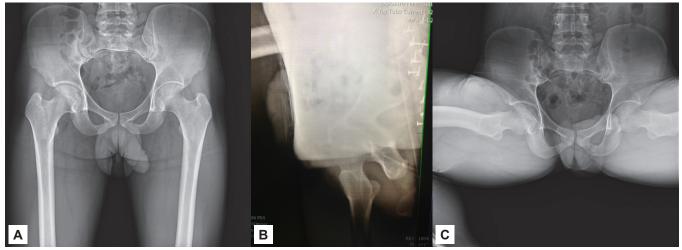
Radiographic views (A) Anteroposterior pelvic view, (B) Cross-table lateral view, (C) 90° Dunn view.
